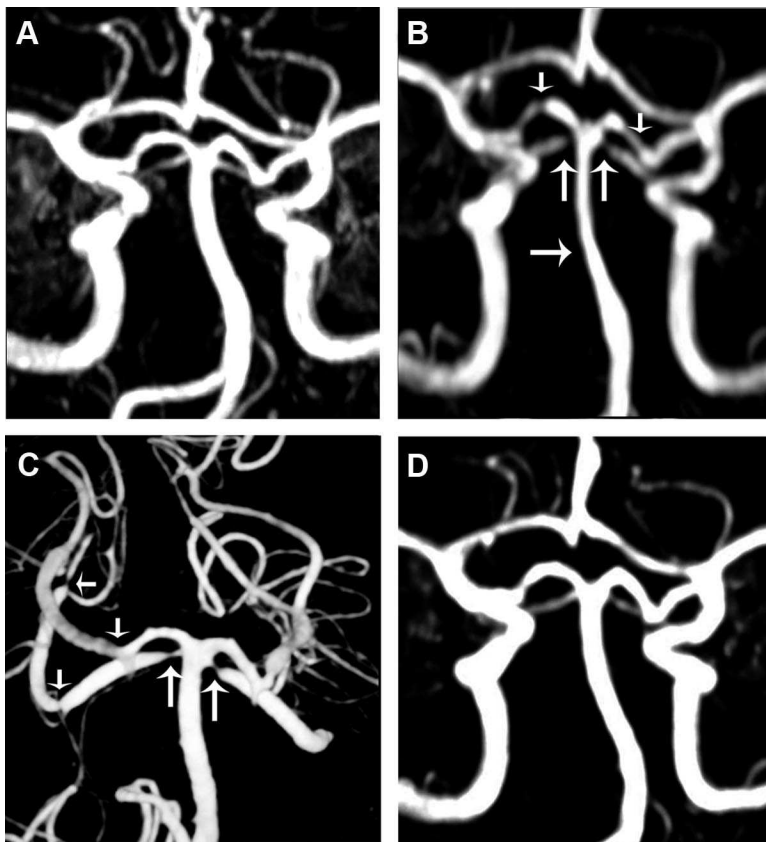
Typical example of the temporal link between cannabis consumption and MIS. Because of his familial history of aneurysm, a cerebral magnetic resonance angiography was performed when he was 19 and was normal (A). At age 20 years, he started smoking cannabis on a weekly basis. At age 21, he was hospitalized for a left cerebellar syndrome associated with unusual headache. Cerebral MRI showed a left cerebellar infarct. Cerebral magnetic resonance angiography disclosed MIS of basilar artery, both posterior cerebral arteries and superior cerebellar arteries (B); that were confirmed on 3D rotational angiography (C). After complete stop of cannabis use, the clinical outcome was favorable. Control cerebral magnetic resonance angiography (D) showed reverse of MIS at 3 months.
